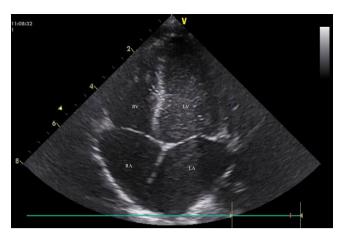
Normal echocardiographic view of Case 2 in her latest examination. LA=left atrium; LV=left ventricle; RA=right atrium; RV=right ventricle.
